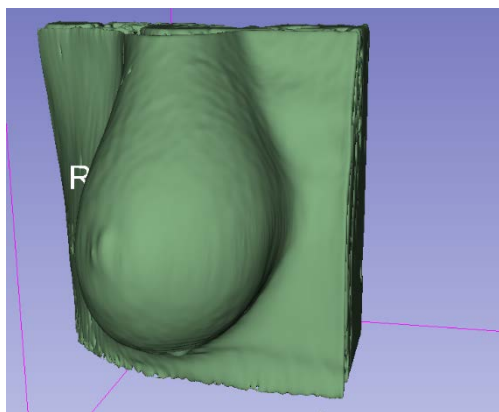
Example of a 3D model generated from a specific MRI scan
